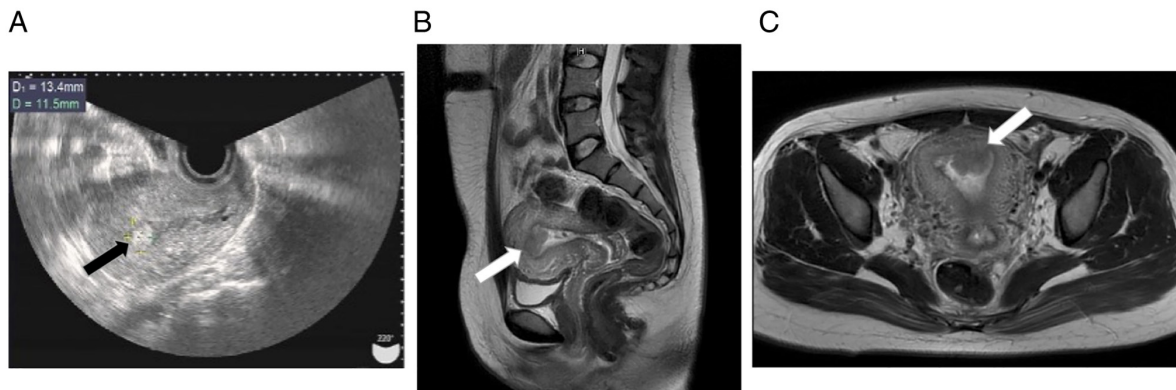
Transvaginal ultrasonographic and MRI findings after 1 month postpartum. (A) Transvaginal ultrasonography demonstrated a high echoic mass of 1.5 cm in the endometrial cavity 1 month postpartum. (B) Sagittal and (C) axial contrast-enhanced T2-weighted MRI revealed endometrial carcinoma measuring 4 cm in diameter with a low signal. The location of the tumor is indicated by an arrow.
